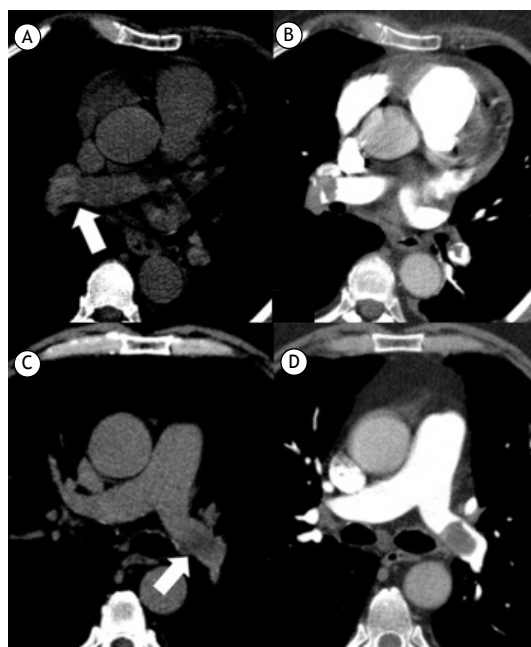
(A and B) Axial chest images in an adapted mediastinal window [window center (WL) = 93; window width (WW) = 284] without administration of contrast medium in A, and CT angiography in B. Hyperattenuating image in the right descending interlobar artery, with a density of 80 HU (arrow in A), confirmed as a thrombus in the CT angiography in B. (C and D) Axial chest images in an adapted mediastinal window without administration of contrast medium in C (WL = 67; WW = 211), and CT angiography in D. Hypoattenuating image in the left pulmonary artery, with a density of 11 HU (arrow in C), confirmed as a thrombus in the CT angiography in D.
